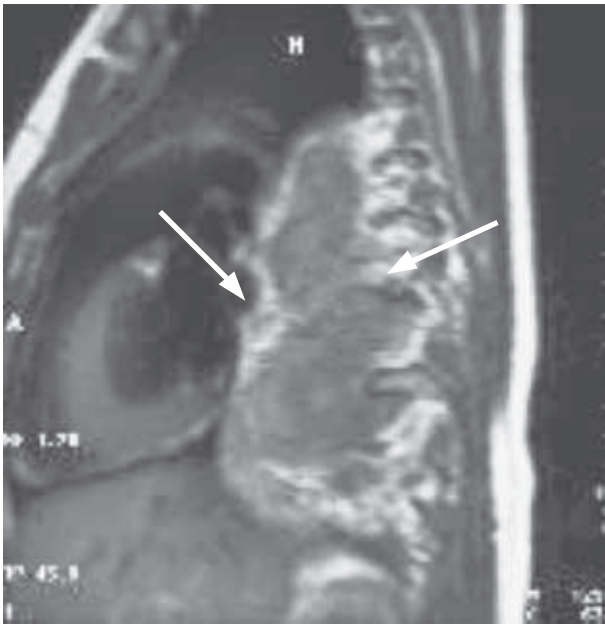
Posterior mediastinum neuroblastoma with tumor penetration into the spinal canal (MRI)
